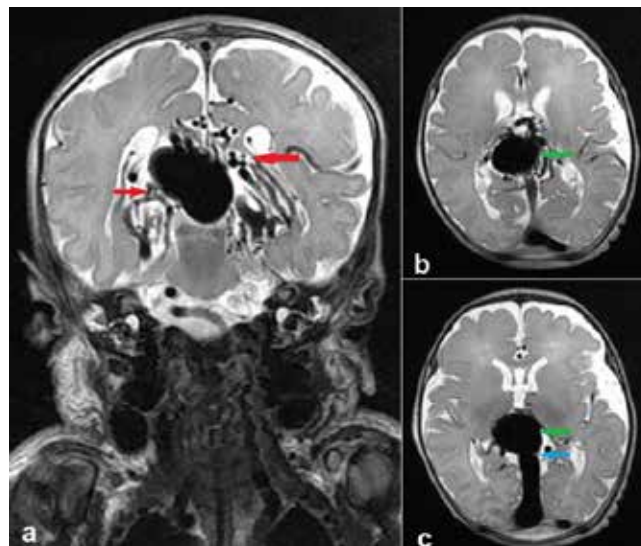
Coronal (a) and axial (b and c) T2-weighted magnetic resonance images demonstrating the Vein of Galen aneurysmal malformation. The feeders of arteriovenous fistulas (red arrows), dilated median prosencephalic vein (green arrow) and persistent falcine draining sinus (blue arrow) are clearly seen.
